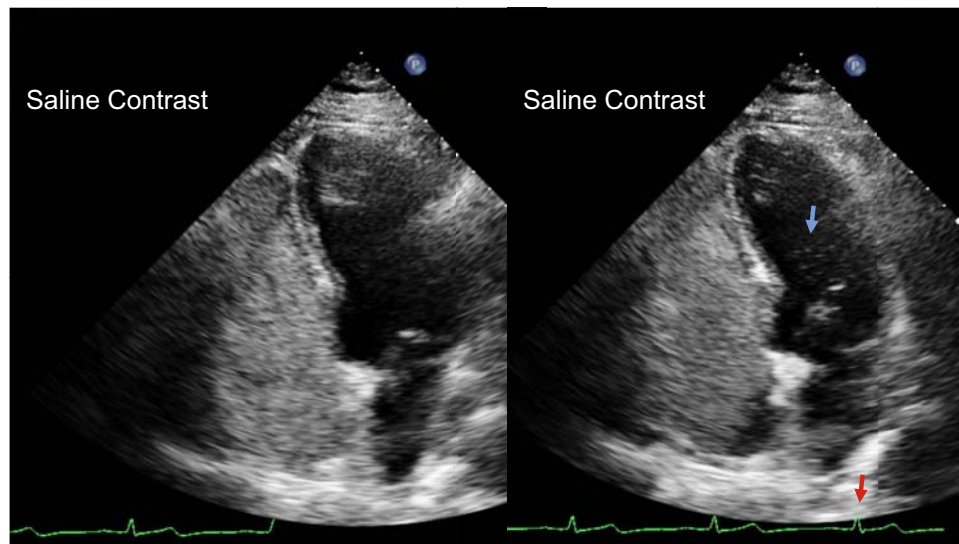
Apical 4-chamber view by transthoracic echocardiography showing a positive bubble study. In the image on the left, the agitated saline bubbles are seen in the right atrium and right ventricle. In the image on the right, saline contrast (*blue arrow*) is visualized in the left ventricle before the third cardiac cycle (*red arrow*), indicative of an intracardiac right-to-left shunt (PFO or atrial septal defect).
